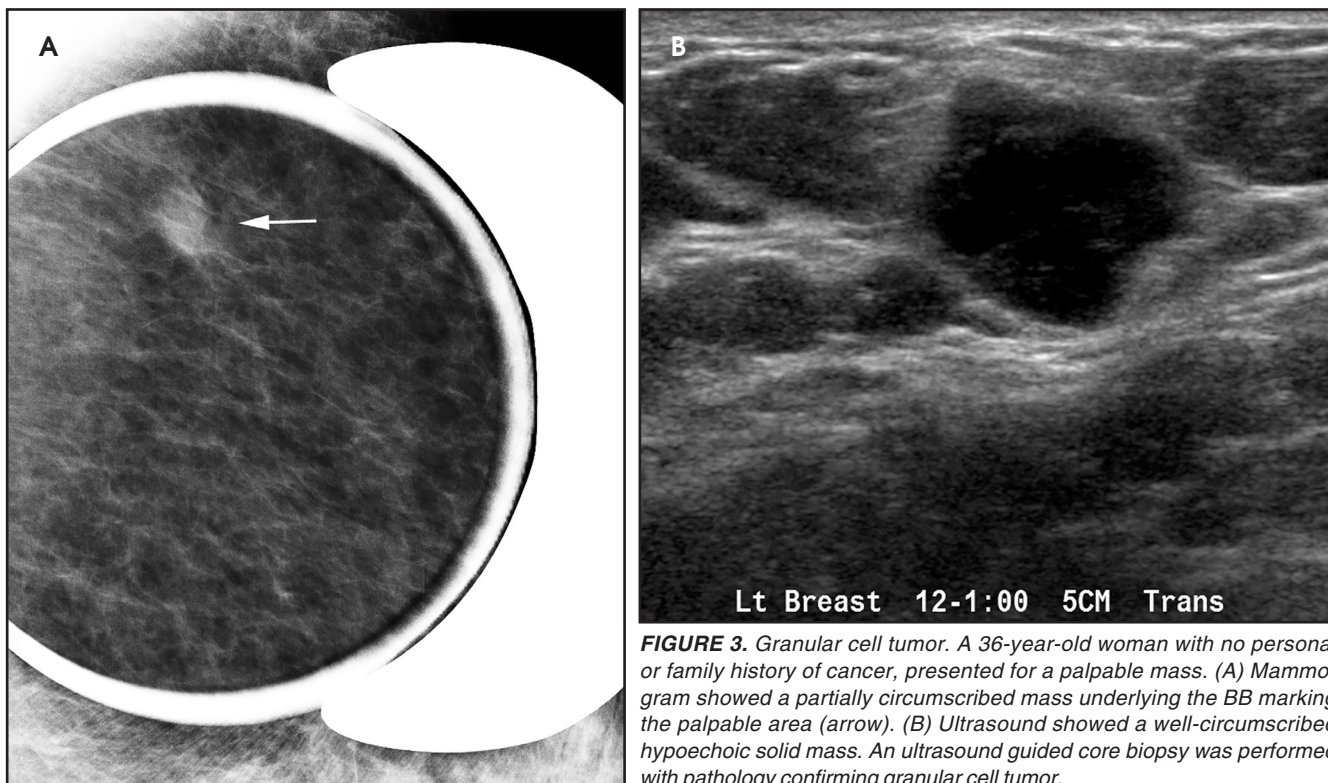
Granular cell tumor. A 36-year-old woman with no personal or family history of cancer, presented for a palpable mass. (A) Mammogram showed a partially circumscribed mass underlying the BB marking the palpable area (arrow). (B) Ultrasound showed a well-circumscribed hypoechoic solid mass. An ultrasound guided core biopsy was performed with pathology confirming granular cell tumor.
